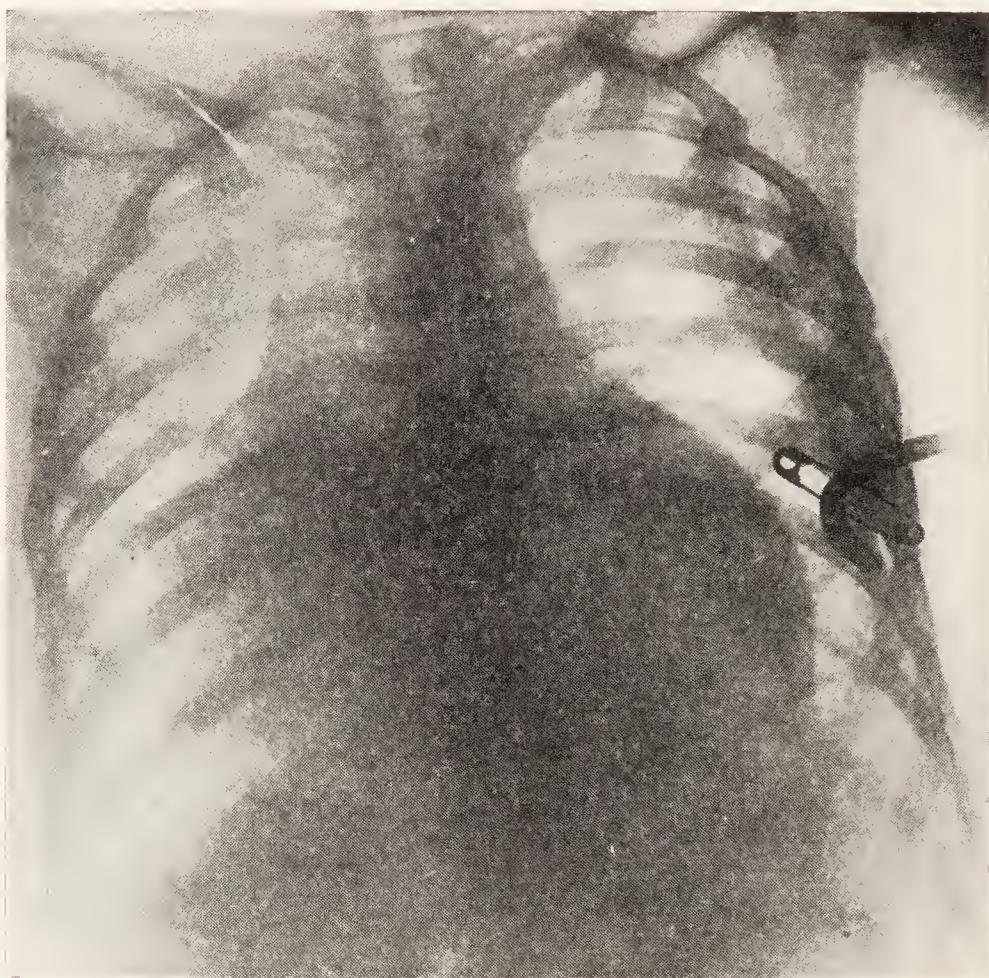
Acute pericarditis. Catheter still in left pleural cavity. Empyema practically gone. Dr. Wyman Whittemore. (Roentgenological Department, Massachusetts General Hospital.)
